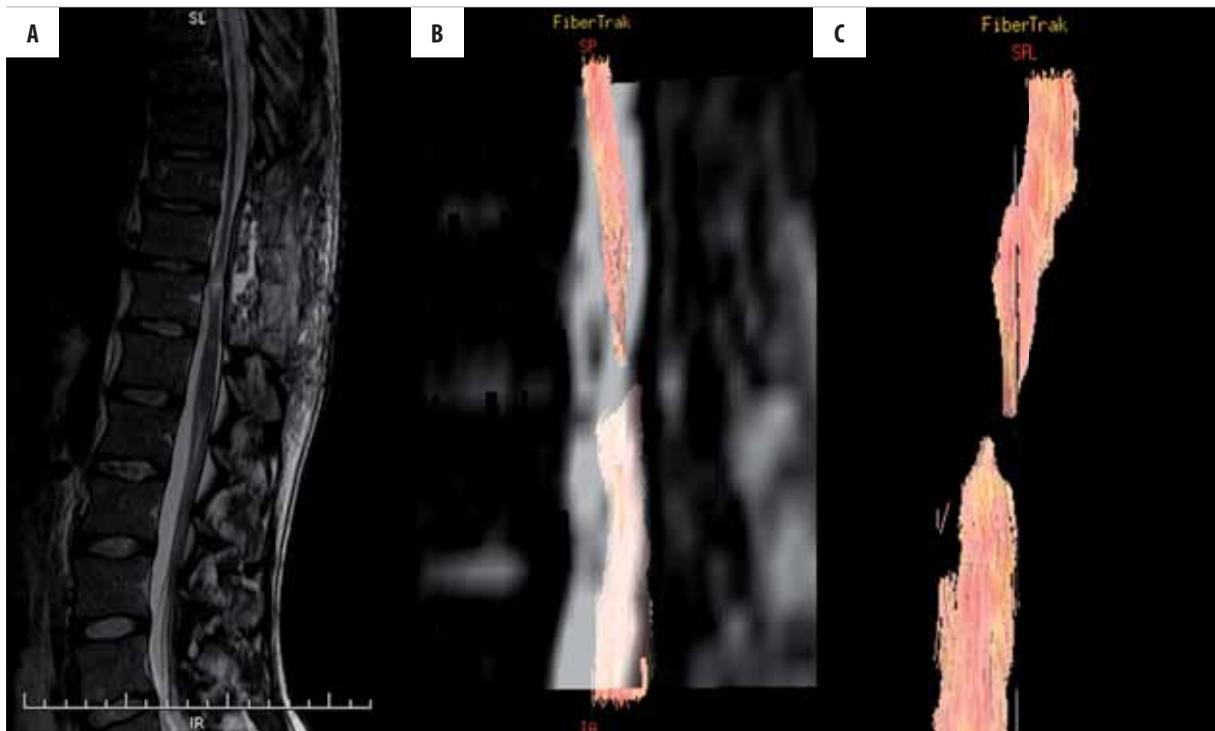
Traumatic injury of the spinal cord. MRI: sagittal T2-weighted image (A) shows thinning of the spinal cord and a hyperintense focus at the T12 level. Diffusion tensor images (B, C) reveal complete disruption of the white matter tracts at the level of the above lesion.
